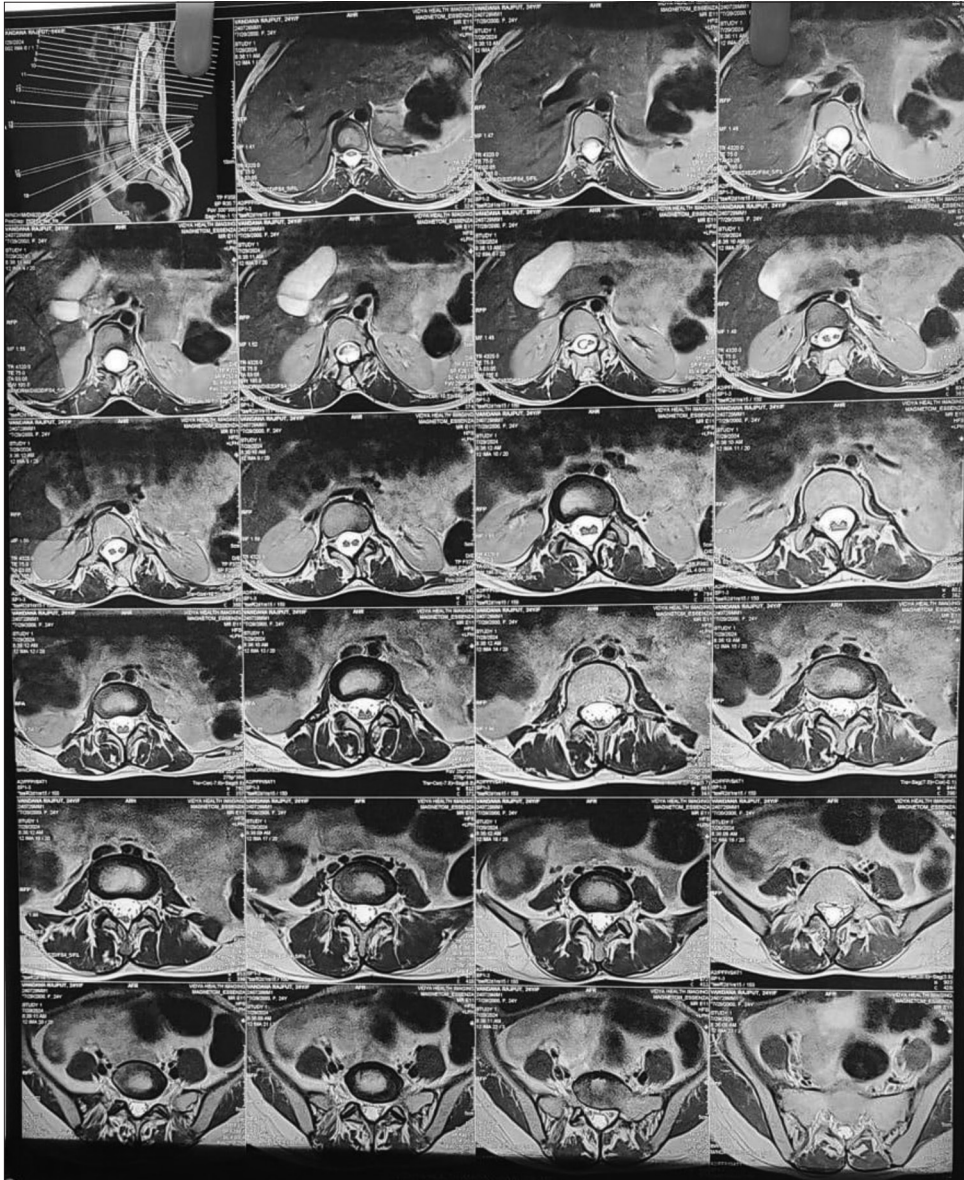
Magnetic resonance imaging of Dorso's lumbar spine with contrast axial view
